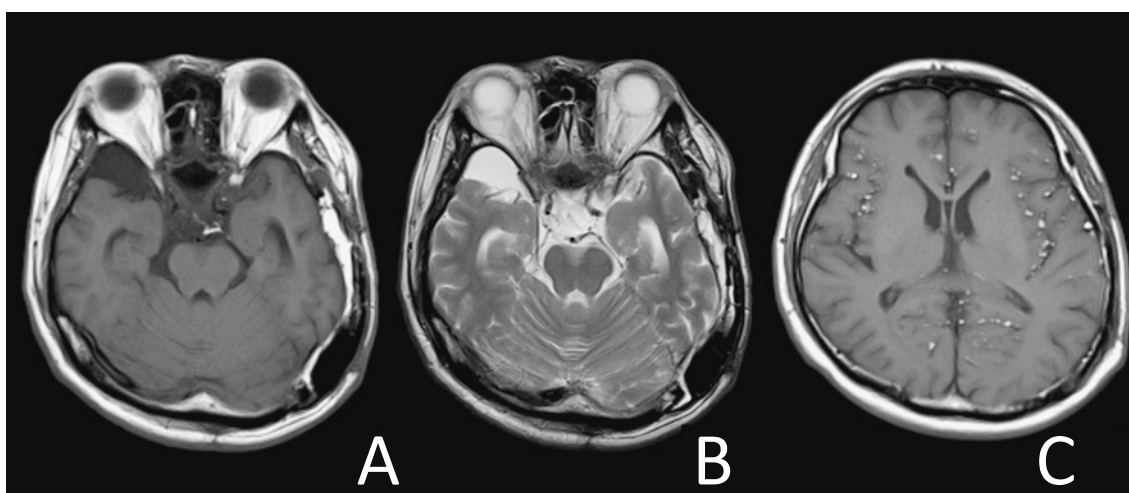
MRI 19 months after surgery.
